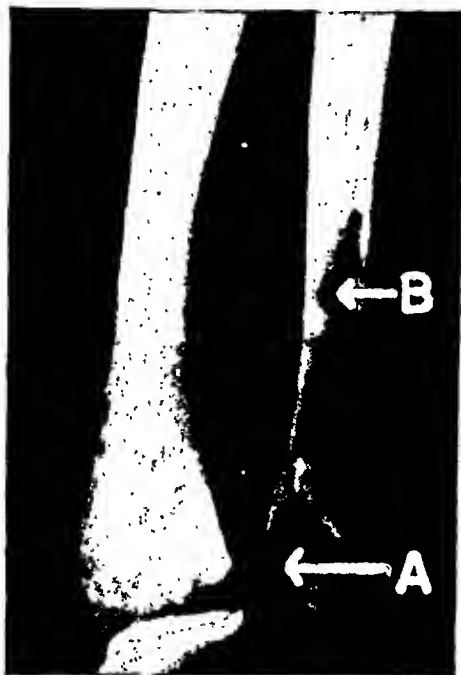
Syndrome X. X-ray of the forearm to show that some bone lesions may be the result of a dyschondroplasia. Note marked irregularity of epiphyseal cartilage at A which strongly suggests that islands of cartilage are being incorporated in the diaphysis. B. represents such an island.
